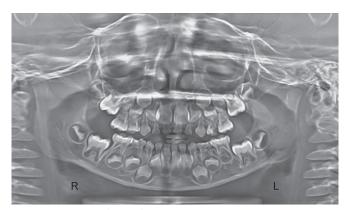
Panoramic radiographic view
